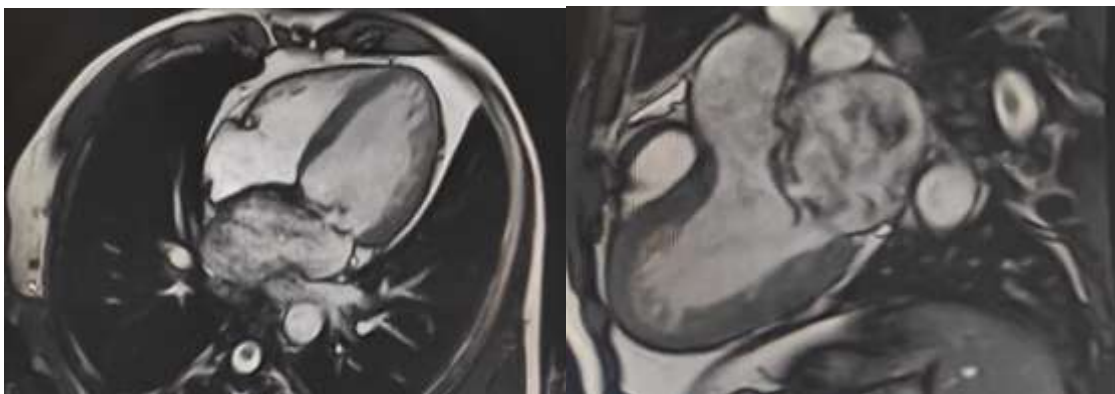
Longitudinal cine cardiac MRI sequences showing the posterior mitral valve prolapsed and the prominent myocardial trabeculations.
